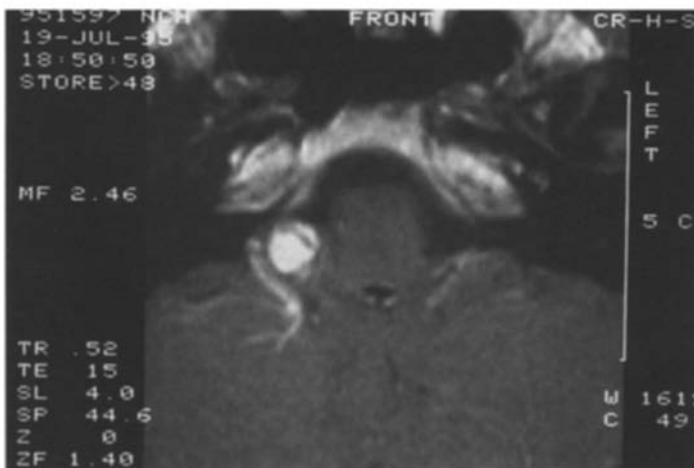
MRI (T1 weighted images after i.v. injection of gadolinium) showing the lesion with a vascular image suggestive of a vein draining from a venous angioma.
